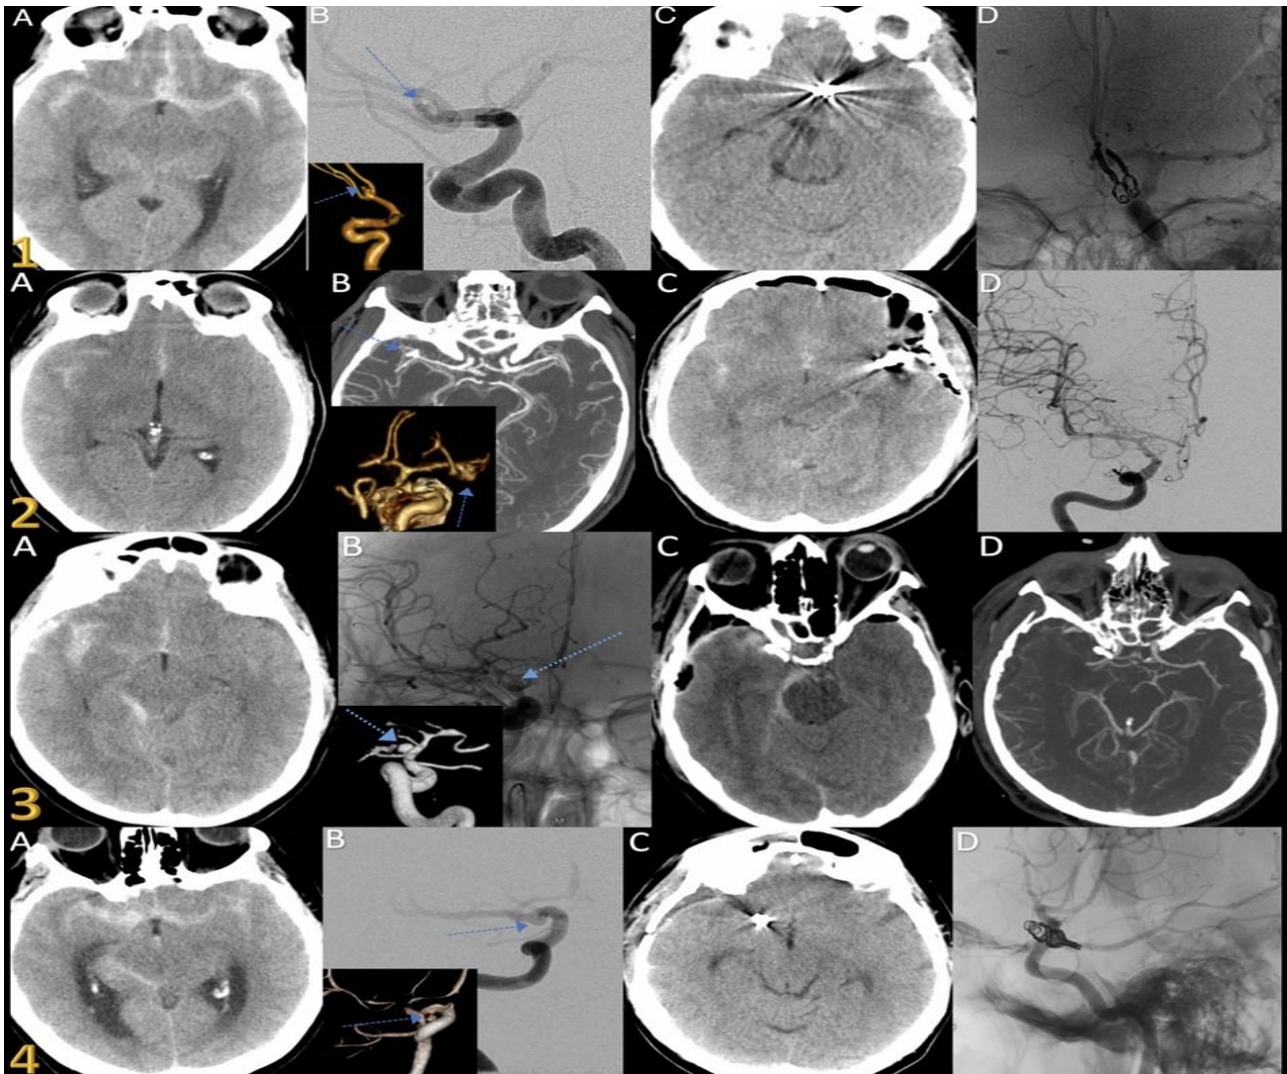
1- A) Preoperative axial CT shows SAH in lamina terminalis, interpeduncular, interhemispheric and sylvian cistern. B) CT and Cerebral angiogram shows a 3.5 mm lobulated anterior communicating artery aneurysm. C) Postoperative CT. D) Postop cerebral angiogram shows no residual aneurysm
